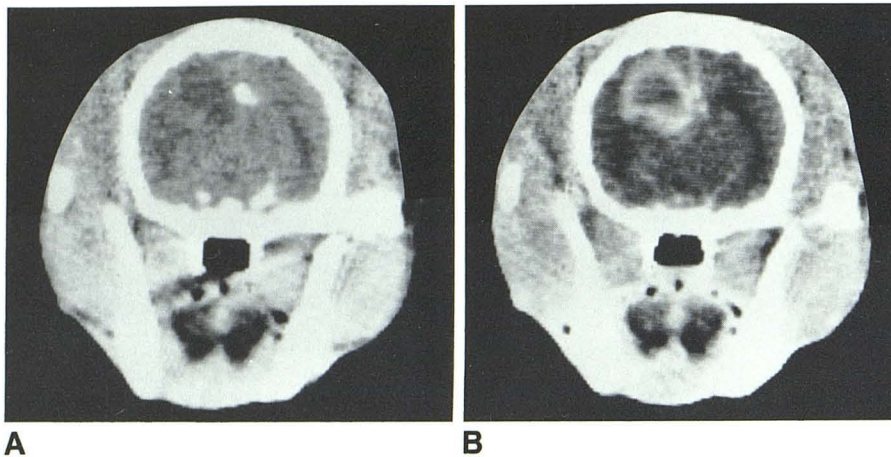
GE 8800 CT scans before (A) and after (B) contrast enhancement with meglumine iothalamate. These images were obtained immediately after MR study fig. 7.
